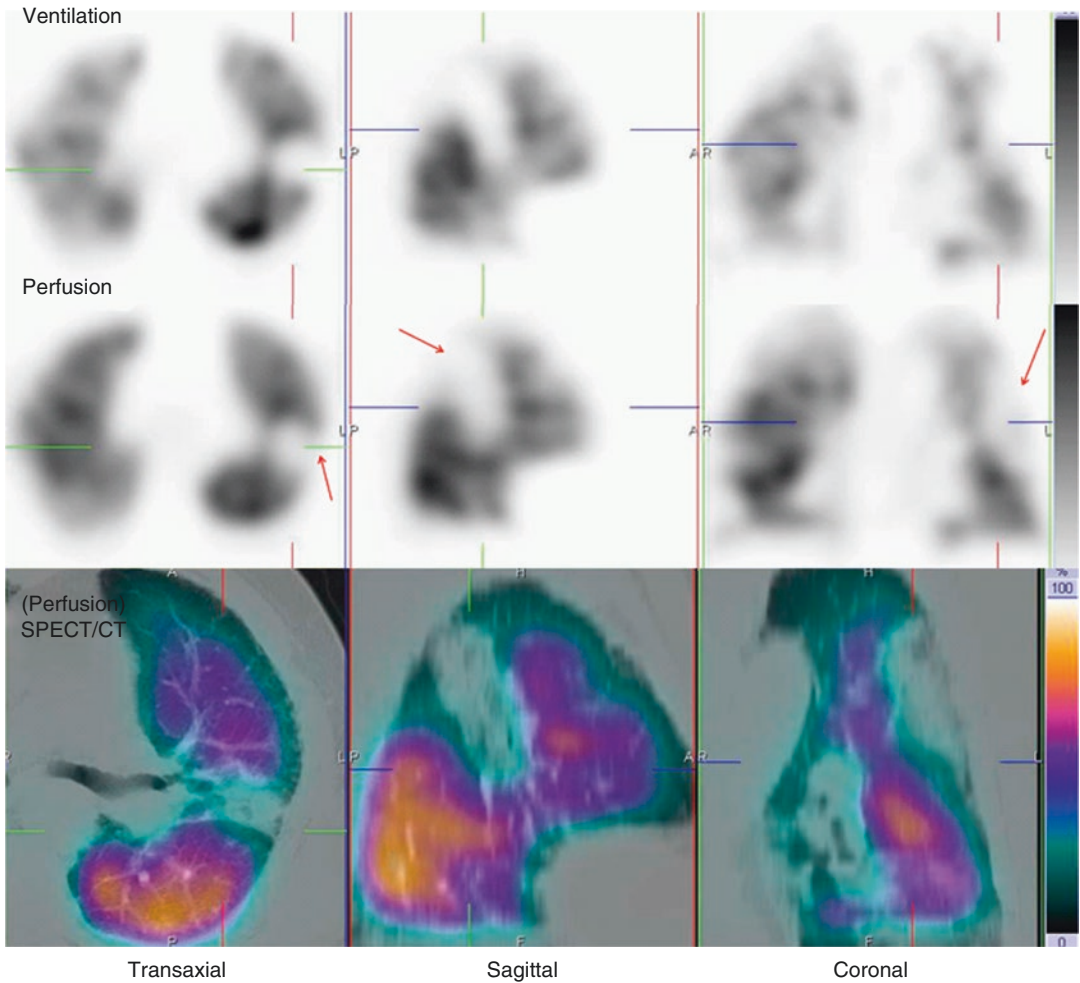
Representative ventilation, perfusion and SPECT/CT images in an 84-year-old male with dyspnea. A large matched defect is evident on SPECT in the left
